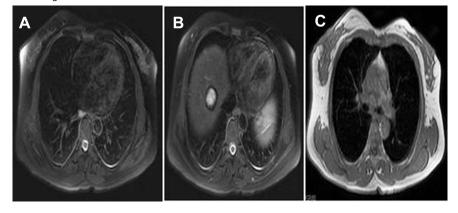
Post treatment MRI: (A) Small focus of restricted diffusion in the left breast inner quadrant; (B) Heterogeneous lesions with restricted diffusion in segment VIII of liver suggestive of residual liver metastasis; (C) Lung parenchyma showed normal densities with no evidence of alveolar densities, intrinsic thickening, fibrosis or emphysematous changes – suggestive of no lung metastasis.
